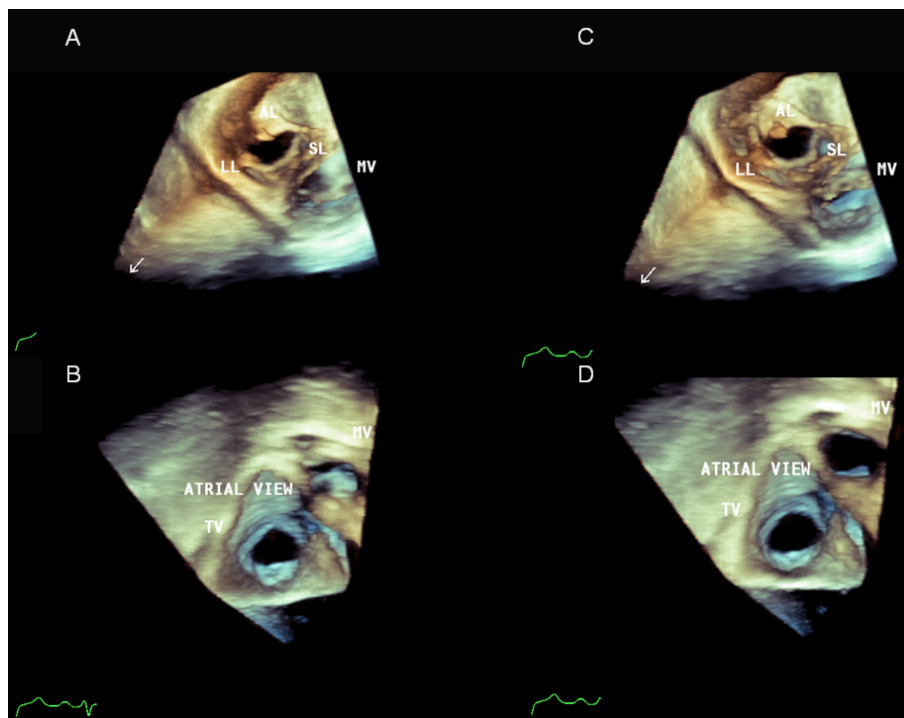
Three-dimensional transthoracic echocardiography after reconstruction, showing the tricuspid valve with diffuse thickening of leaflets, shortening of chordae and apical traction with systolic coaptation deficit. A and C: Ventricular view showing the tricuspid and mitral valves during diastole; B and D: Atrial view showing the tricuspid and mitral valves during systole.
